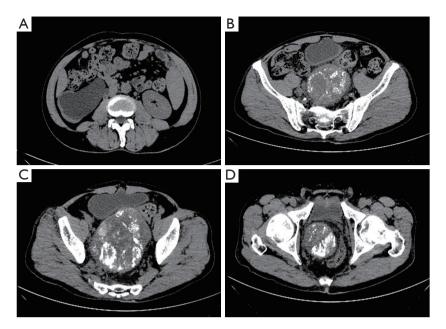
The CT examination results of different planes. (A) The sign of right hydronephrosis. (B-D) Different layers of the pelvic SFT. CT; computed tomography; SFT, solitary fibrous tumor.
